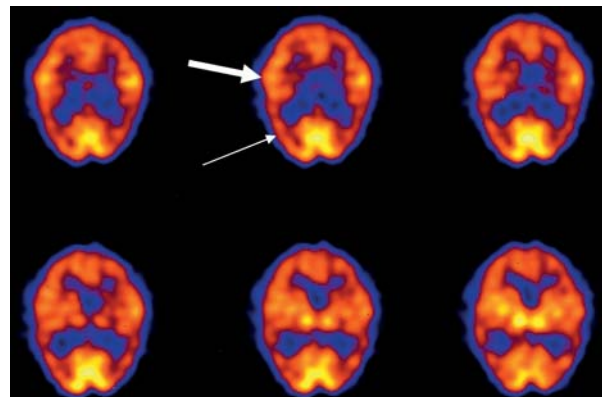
Transaxial SPECT images of $^{99\text{m}}\text{Tc}$ bicasate in a patient with late Alzheimer's disease (AD). There is moderately decreased perfusion in both temporoparietal regions (thin arrow) in comparison to the control studies shown in previous figures. In this later stage of AD, there is also decreased perfusion in the frontal lobes with preservation of perfusion only in the sensorimotor areas (thick arrow), visual cortex, and subcortical structures.
